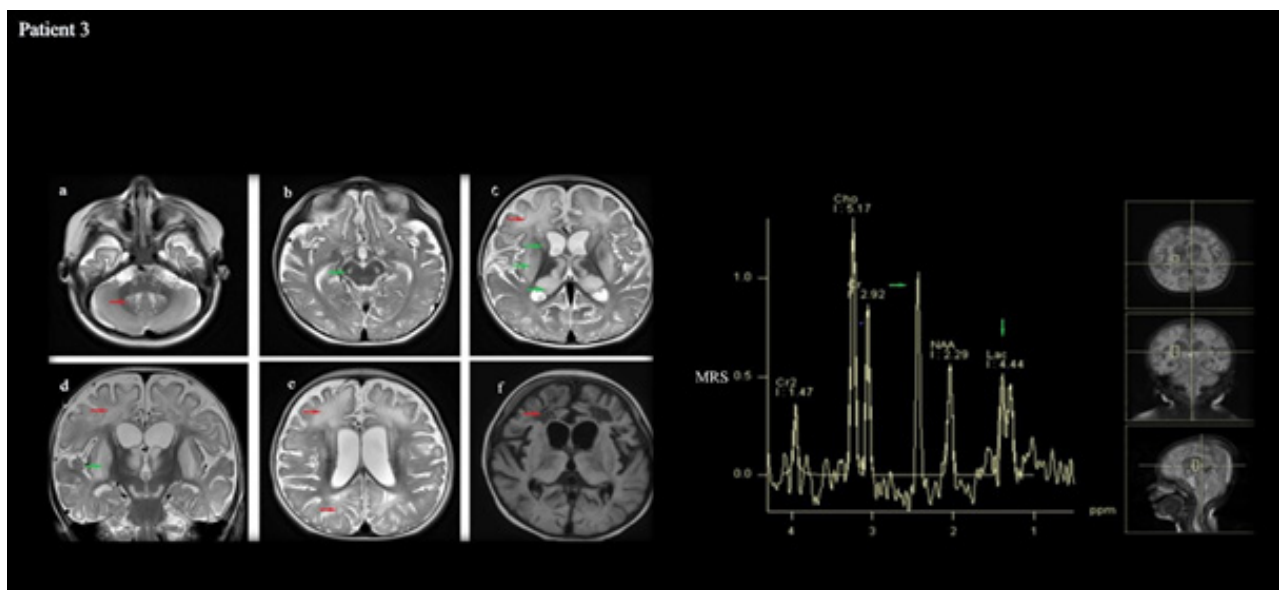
MRI images of Patient 3: Hyperintense T2 signal changes in the frontal, parietal, occipital cerebral white matter (red arrows on the c, d, e, f), corpus striatum, thalamus (green arrows on the c, d), dentate nucleus (red arrow on the a), substantia nigra (green arrow on the b)
